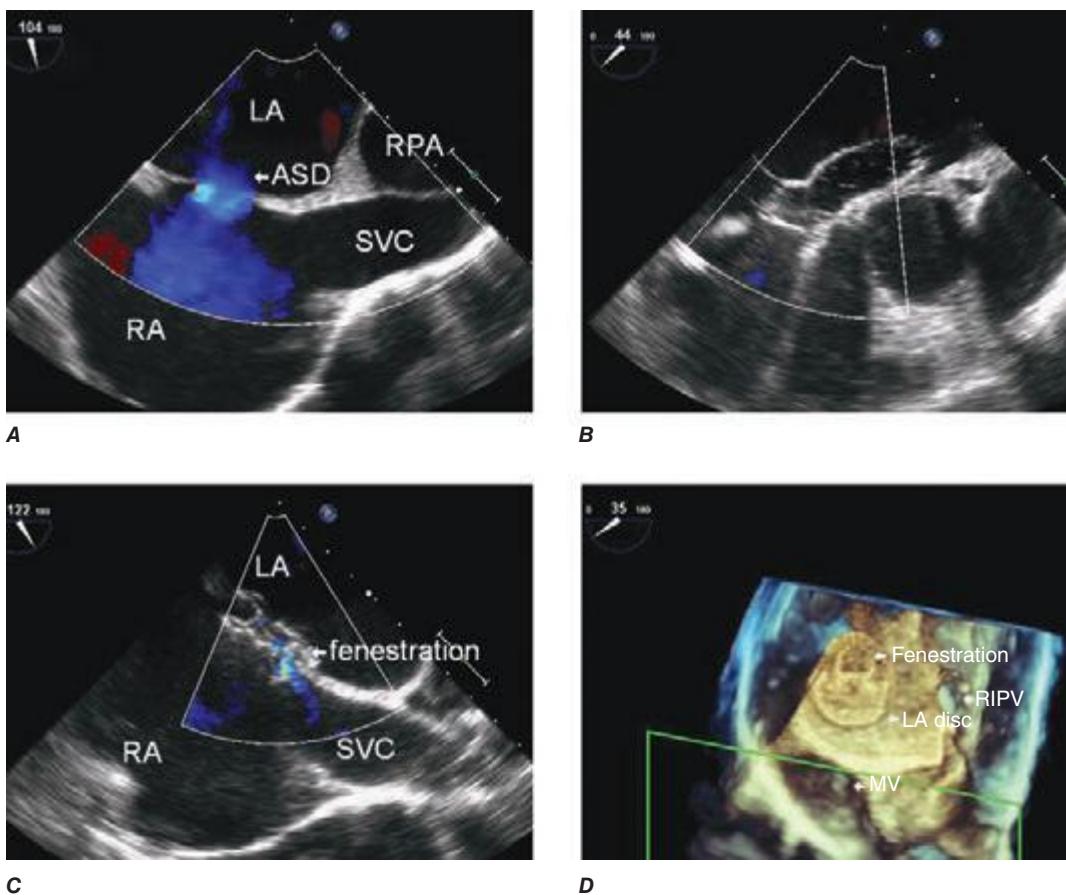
A. Transesophageal echocardiogram demonstrating a secundum-type atrial septal defect (ASD) with shunting from the left atrium (LA) to the right atrium (RA). The right pulmonary artery (RPA) and superior vena cava (SVC) are labeled. B. Transcatheter balloon sizing of the ASD. C. Atrial septal occluder placement with a small manually created “fenestration” within the device that continues to allow a small amount of flow from the LA to the RA; this is used as a means of preventing left atrial hypertension after ASD closure. Left atrial hypertension may occur in older patients with decreased left ventricular compliance. D. Three-dimensional image of the septal occluder en-face; note the fenestration in the LA disc. The mitral valve (MV) and right inferior pulmonary vein (RIPV) are labeled.
